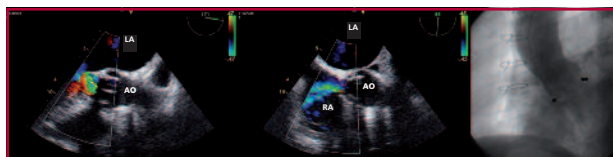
Aortic (AO) paravalvular leak (left) and fistula to the right atrium (RA) (middle) in transesophageal echocardiography. Paravalvular leak () and fistula (*) in angiography (right).
